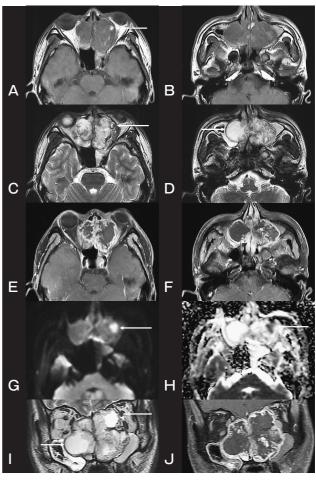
T1-weighted axial images (A,B), T2-weighted axial images (C,D), contrast-enhanced axial images (E,F), diffusion-weighted image (DWI, b=800 sec/mm²; G), apparent diffusion coefficient (ADC) map (H), T2-weighted coronal image (I), and contrast-enhanced coronal image (J).
